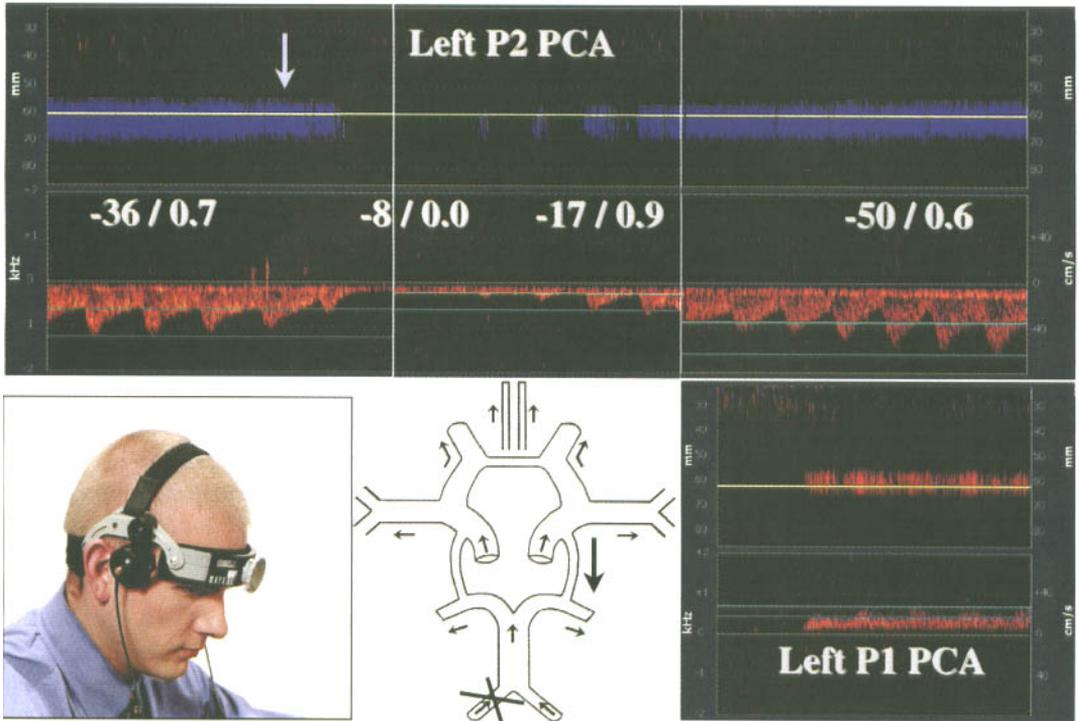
Sequential motion-mode and spectral transcranial Doppler recordings from P2 posterior cerebral artery during a true positive test for vertebral artery compression
